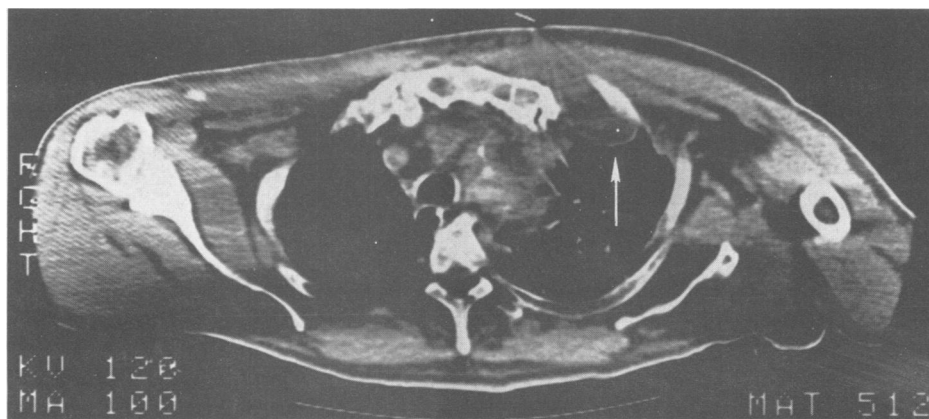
A computed tomographic scan at the level of the sternoclavicular joint shows a mass extending posteriorly (arrow), with anterior chest wall swelling and an inflammatory process of the mediastinum causing tracheal deviation.
